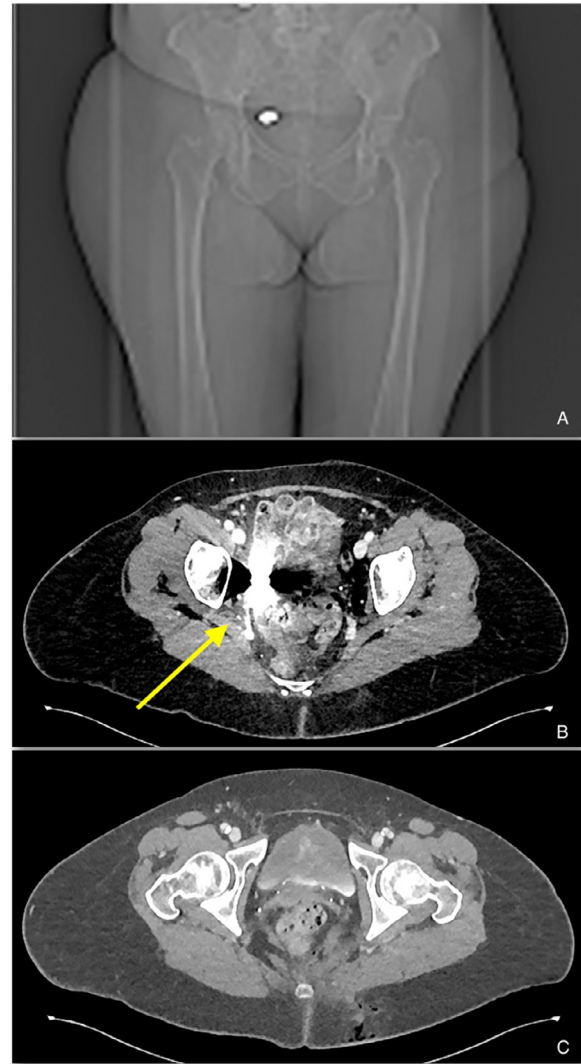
(A-C). Frontal CT scout view (A) and axial CT images enhanced with intravenous contrast (venous phases) of the bullet's location and entry wound. The bullet was lodged in the right pelvic sidewall, determining severe beam-hardening artifact (yellow arrow). Foci of gas and surrounding stranding within the subcutaneous fat were detected in the left gluteal region associated with the defect of the cutaneous plane, indicating the entry wound.
